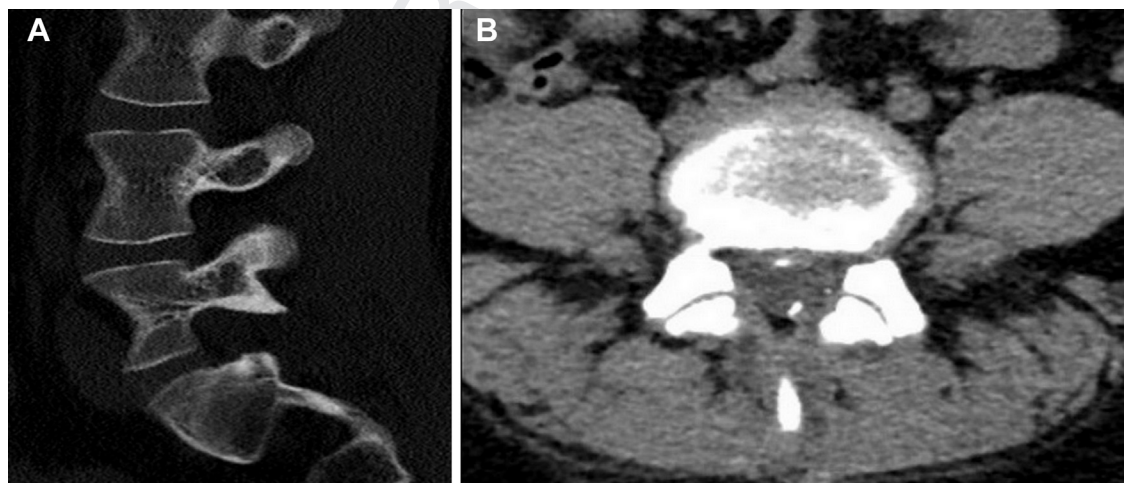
Postoperative computed tomography scan showing complete decompression of the L5 left foramen (A) and a few
